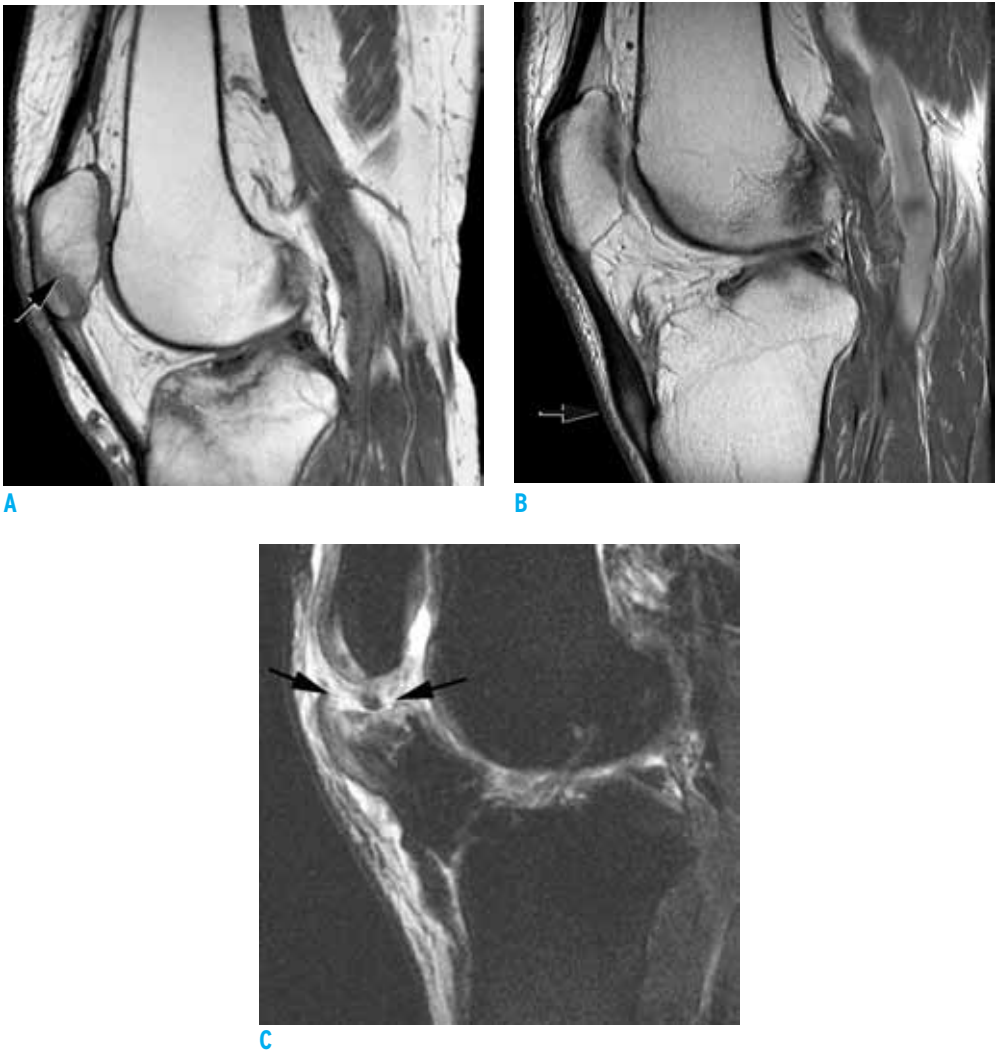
MRI tissue weighting. (A) A sagittal T1-weighted image demonstrating bone marrow edema (arrow) consistent with a stress fracture. (B) A sagittal proton-density-weighted image demonstrating thickening of the patellar tendon (arrow) consistent with patellar tendinitis. (C) A sagittal T2-weighted, fat-suppressed image demonstrating a tear within the proximal patellar tendon (arrows). The altered signal intensity above the arrows indicates edema.
